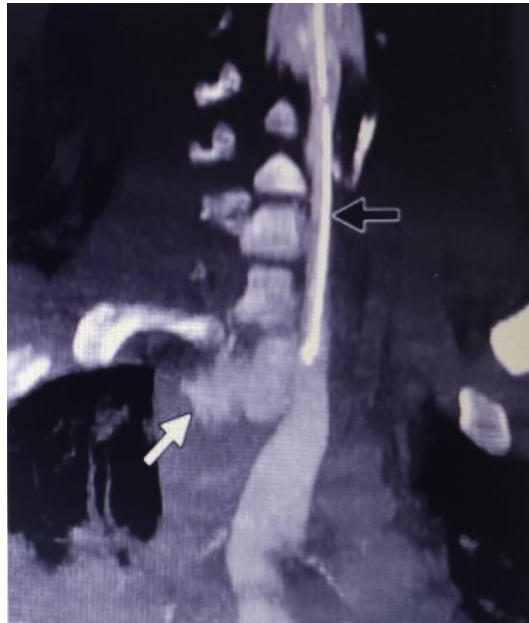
Bullet blind transmediastinal injury. Rupture of the esophagus. A. X-ray: wound channel from the left supraclavicular area (white arrow) to the apex of the right lung (black arrow). B. MDCT – coronal projection, esophageal probe (black arrow), leakage of contrast material to the mediastinum through a defect in the esophageal wall (white arrow).
